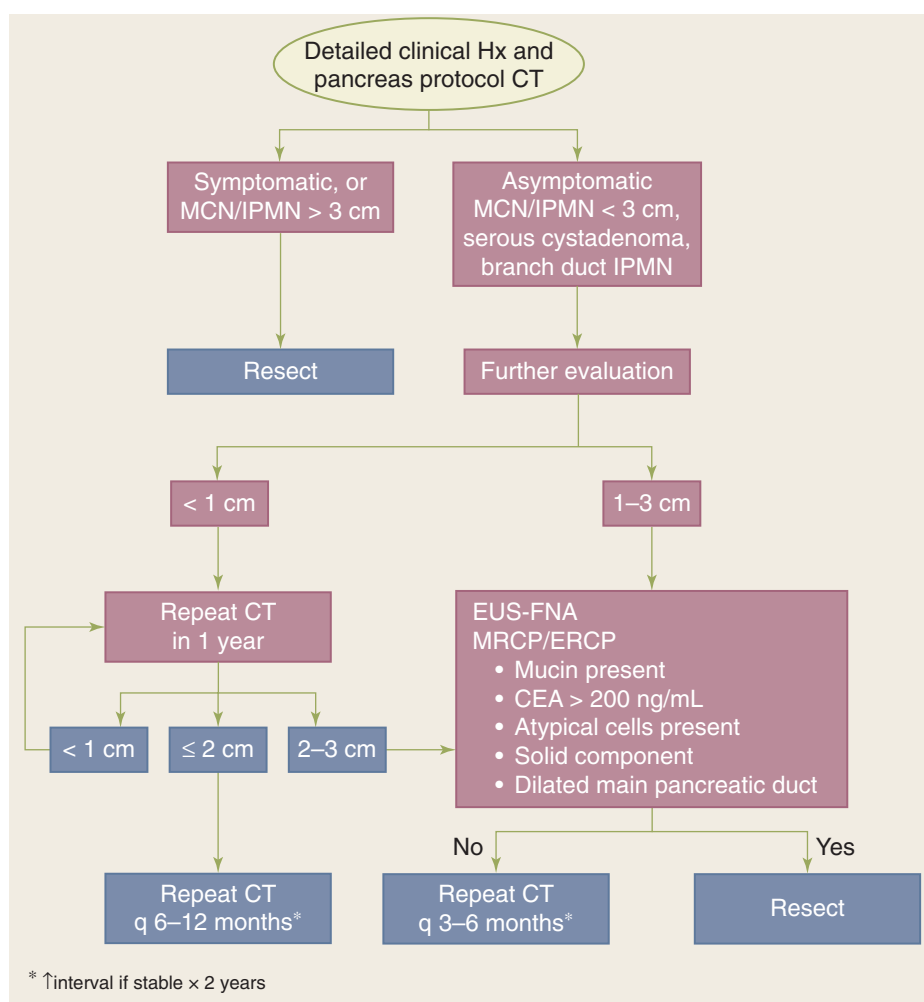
Algorithm for management of pancreatic cystic neoplasms. CEA = carcinoembryonic antigen; CT = computed tomography; ERCP = endoscopic retrograde cholangiopancreatography; EUS = endoscopic ultrasound; FNA = fine-needle aspiration; Hx = history; IPMN = intraductal papillary mucinous neoplasm of the pancreas; MCN = mucinous cystic neoplasm; MRCP = magnetic resonance cholangiopancreatography.
